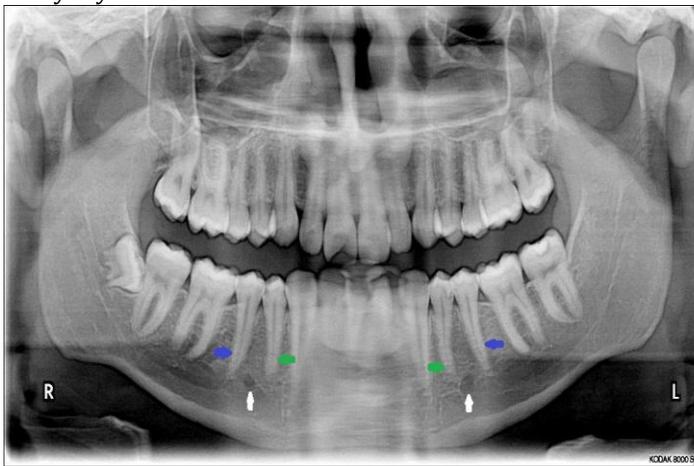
Panoramic radiograph shows the location of mental foramen (white arrow) is present in between first (green arrow) and second (blue arrow) premolar on both right and left side indicating bilateral symmetry.
